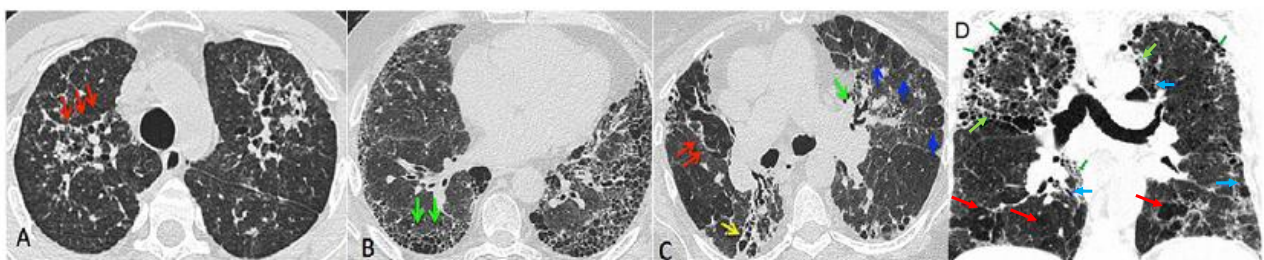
HRCT of CHP patients [13].
